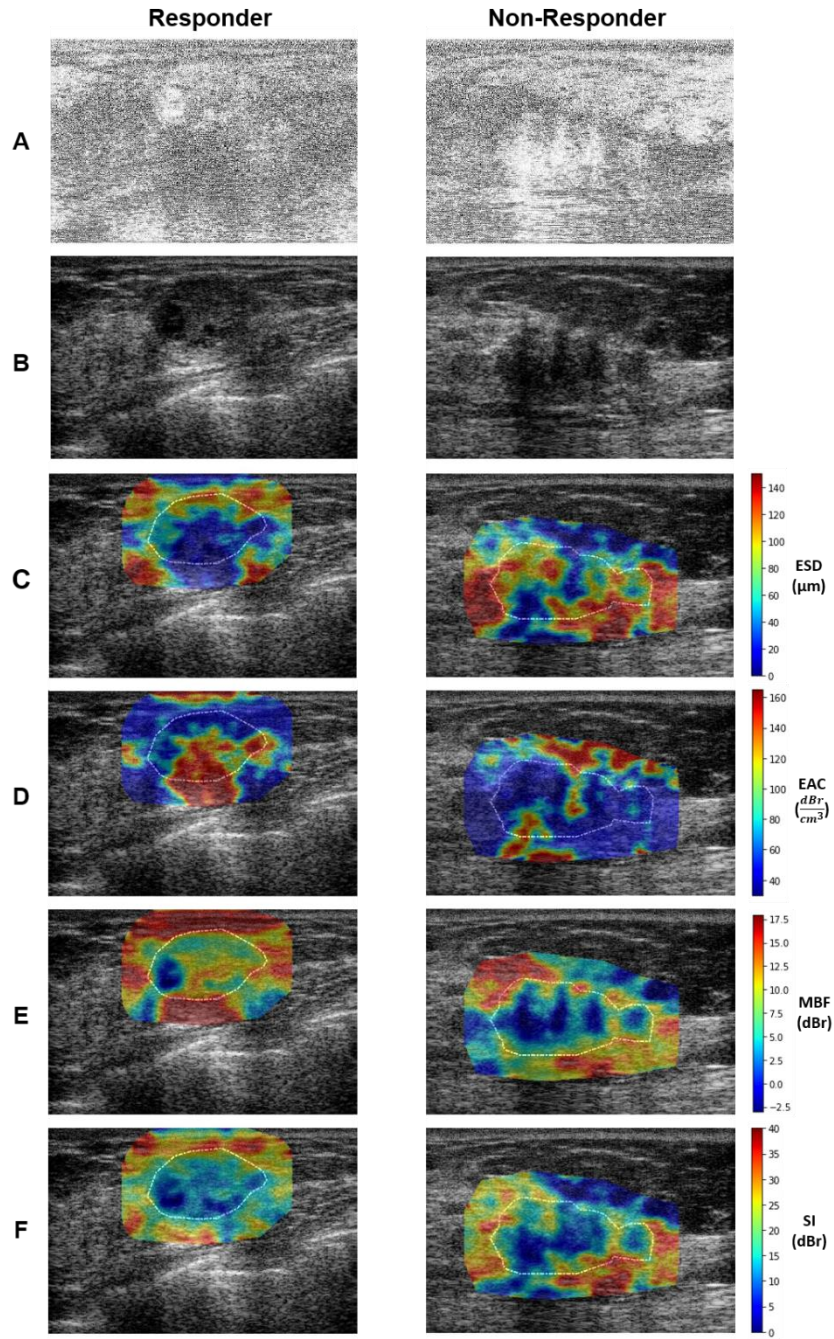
Ultrasound RF data (A), B-mode images (B), and QUS parametric images of ESD (C), EAC (D), MBF (E), and SI (F) obtained for a representative responder and non-responder to NAC. The tumor core has been outlined with white dashed line on the parametric images.
